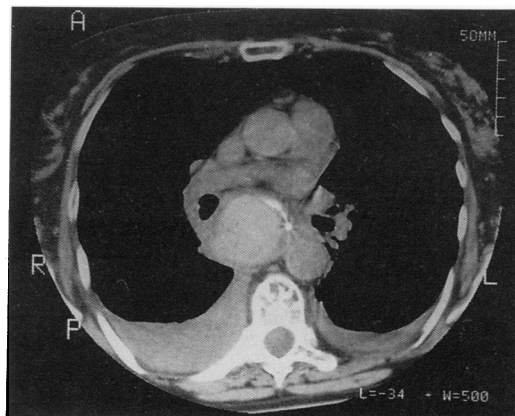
Computed tomogram of the upper thorax: grossly distended oesophagus with radio-opaque feeding tube anteriorly, compression of the trachea, and bilateral pleural effusions.
